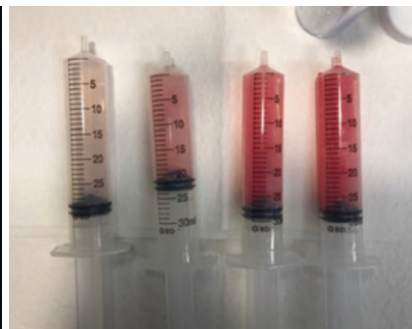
Radiographic and bronchoscopic features of diffuse alveolar hemorrhage. Left: characteristic chest X-ray showing diffuse bilateral pulmonary infiltrates.
